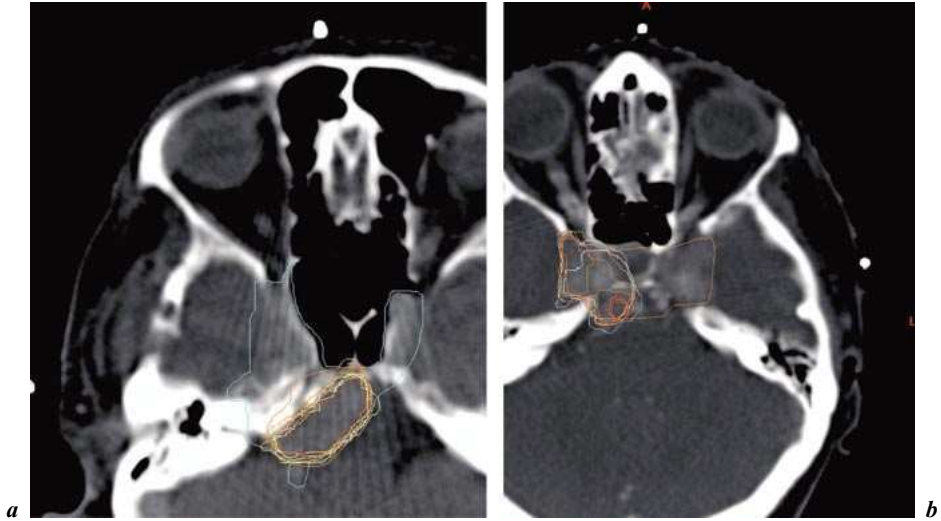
GTV delineations of the eight observers on a transverse CT slice for the first (a) and second (b) patient.
